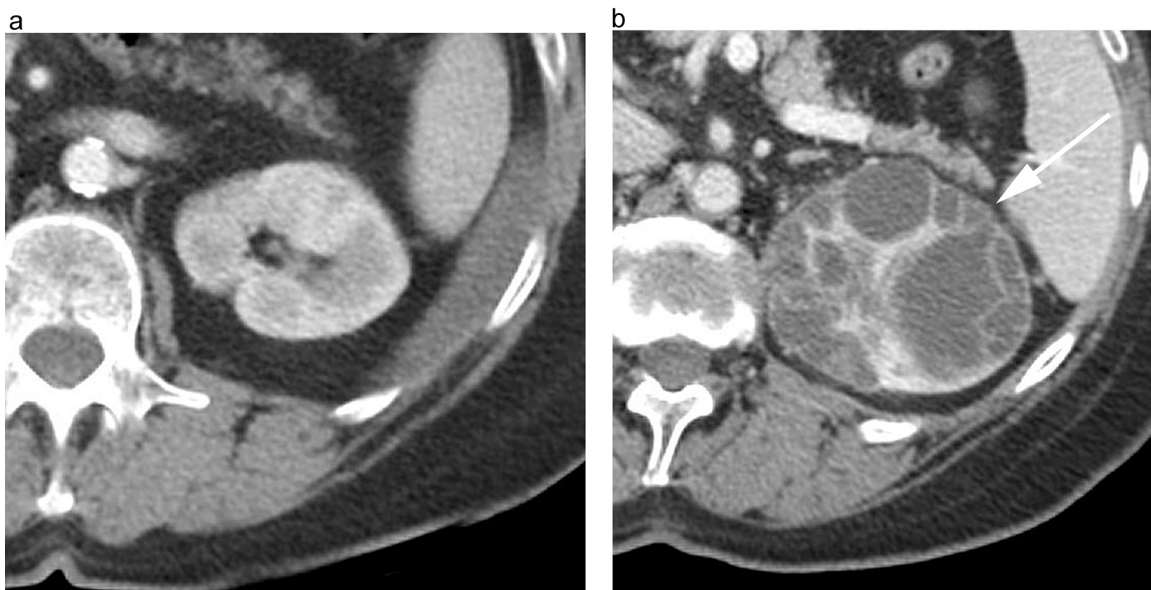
(a) and (b) Axial post contrast CT images of the left kidney in a 68 year old female patient, before crizotinib treatment (Fig. 1a) and 10 months after crizotinib treatment (Fig. 1b). The post treatment image demonstrates the development of a complex cystic lesion with numerous internal septations, some of which were thickened and had measurable enhancement (Bosniak category 3).
